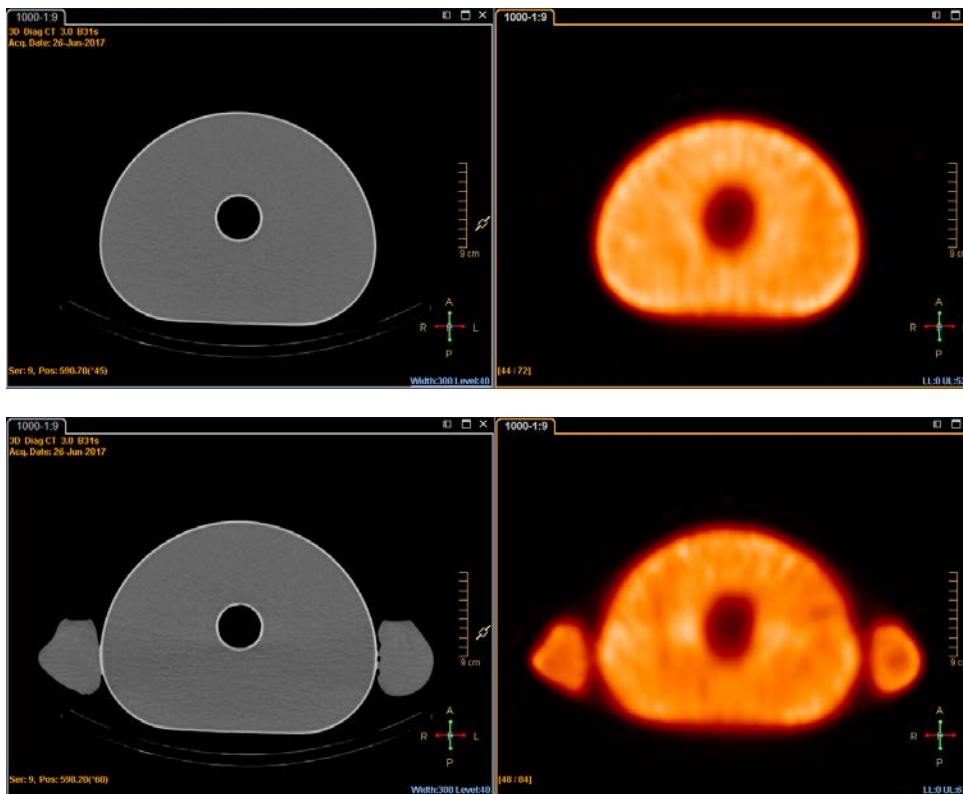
CT scan of 130 kV and 170 mAs only a faint shadow is observed in the CT image, even with the arms down, and the influence on SPECT is negligible.
